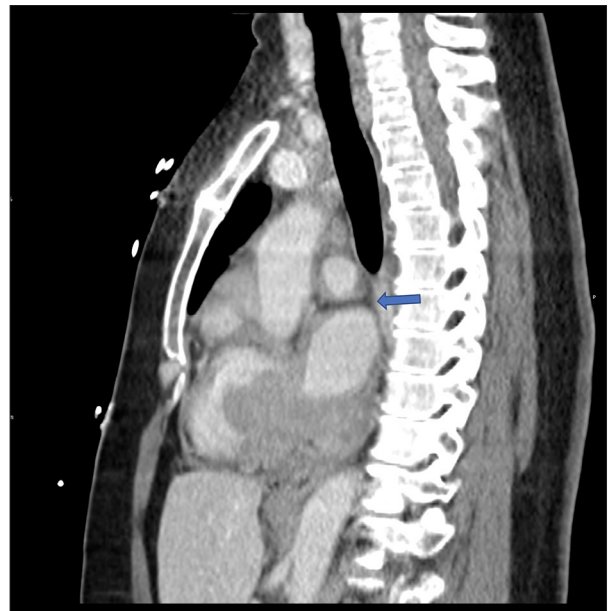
Computed tomography with sagittal view. There is posterior mediastinal involvement with no radiographic evidence of a fat plane separating the intracardiac mass and the esophagus (arrow).
